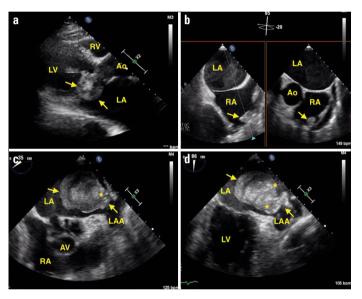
(a) Transthoracic echocardiography parasternal long axis view showed left atrial mass (b) Transesophageal echocardiography in midesophageal bicaval view showed the right atrial appendage mass (arrow) (c) Transesophageal echocardiography in midesophageal short axis view showed a left atrial mass (arrows) attached to the coumadin ridge and calcific nodules (asterisk) (d) Transesophageal echocardiography in midesophageal two-chamber view showed a left atrial mass (arrows) attached to the coumadin ridge and calcific nodules (asterisk)
